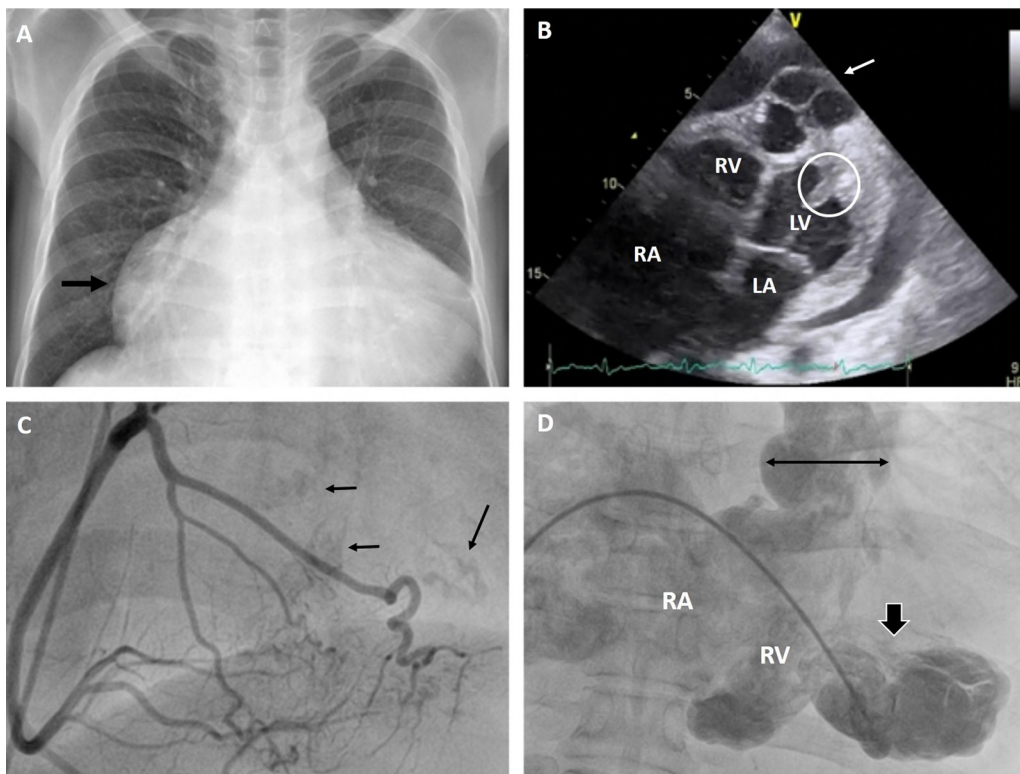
(A) Chest radiograph. Note the enlargement of cardiac silhouette due to significant right atrial dilatation (arrow). Left atrial enlargement is also noted. (B) 2D echocardiogram modified apical 4-chamber view. Left atrium is enlarged (size 46 mm). Left ventricular apex is obliterated with calcification (encircled). Note enlarged right atrium (size 54 mm) and large aneurysm at right ventricular apex (arrow) with multiple septations. Significant pericardial effusion is noted. (C) Arrows delineate endocardial calcific deposits on the left ventricle detected during coronary angiography. Epicardial coronaries are free of lesion. (D) Cine angiographic frames of the right ventricle in the postero-anterior view at systole showing large apical aneurysm with septations (single headed arrow). Right atrium is dilated. Note the dilated right ventricular outflow tract (double headed arrow). (E) Cine angiographic frames of the left ventricle in the right anterior oblique view at end-diastole showing obliteration of ventricular apex. (F) Pressure tracings of right atrium showing classical 'CV waves' with prominent 'y' descent (Arrow). (G) Pulmonary artery pressure tracings showing pulmonary artery systolic pressure of 28 mm Hg. (H) Pull-back pressure tracing from right ventricular aneurysm to the ventricular cavity proper showing a pressure gradient of 15 mm Hg (arrow). RA – right atrium, RV – right ventricle, LV – left ventricle.
